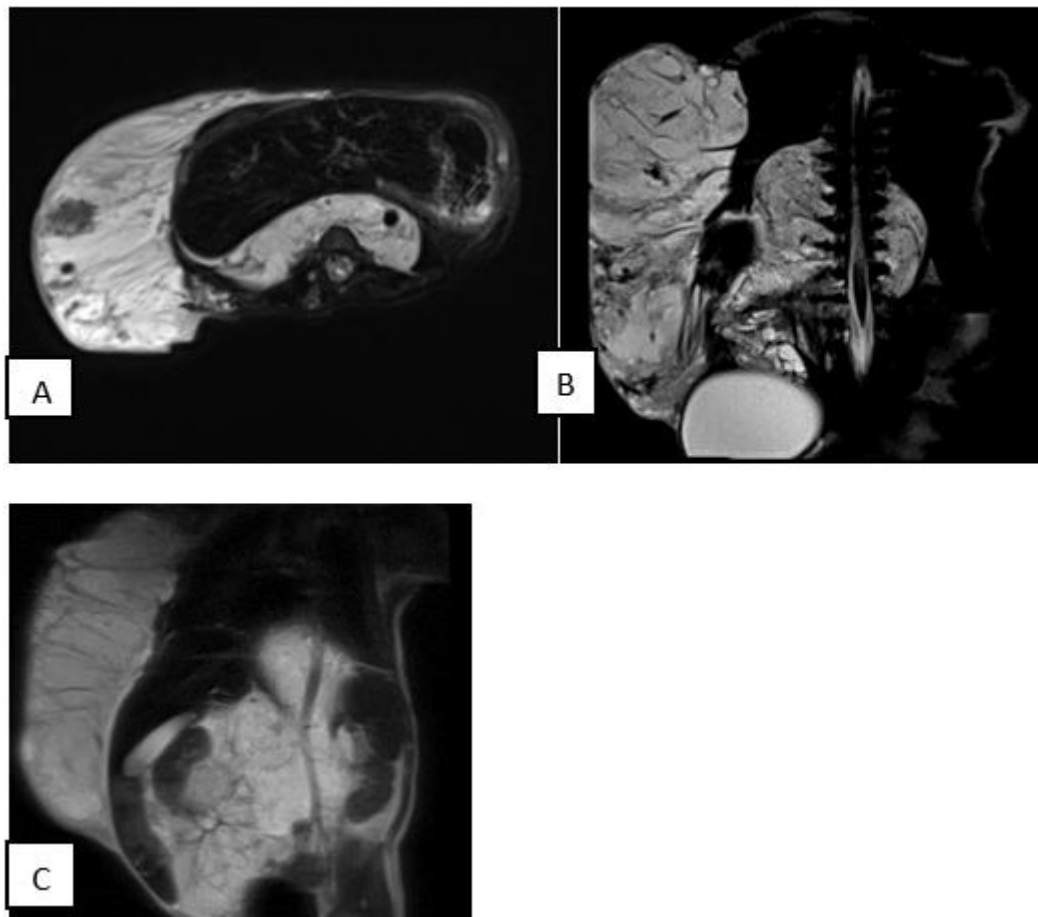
A–C. Axial and coronal T2-weighted MRI images of the abdomen at the level of the liver demonstrate a well-defined, encapsulated giant mass that is predominantly hyperintense with internal signal voids. The mass is confined to the subcutaneous tissues, extending from the anterior, lateral, and posterior chest wall to the pelvic region
